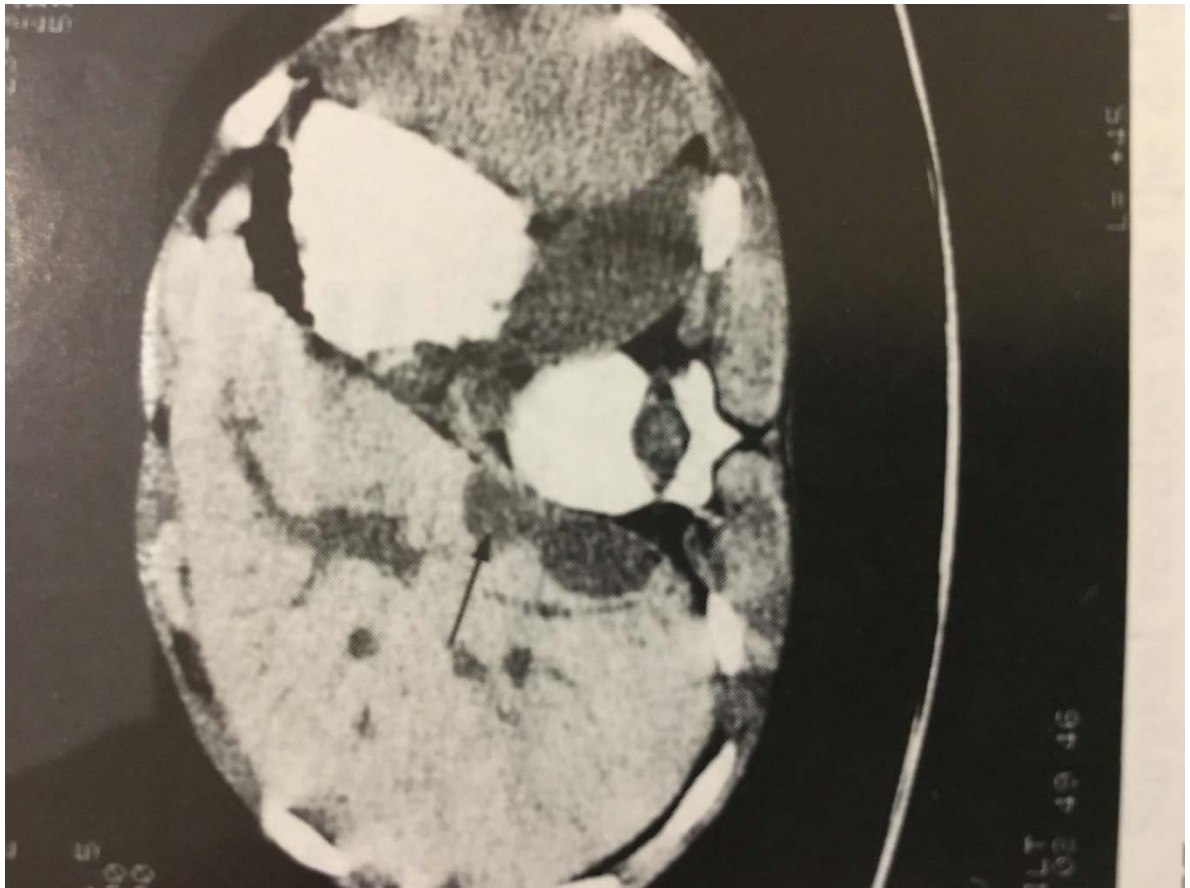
Computed tomography (CT) scan of abdomen reveals right adrenal mass which proved to be estrogen secreting abdomen.
